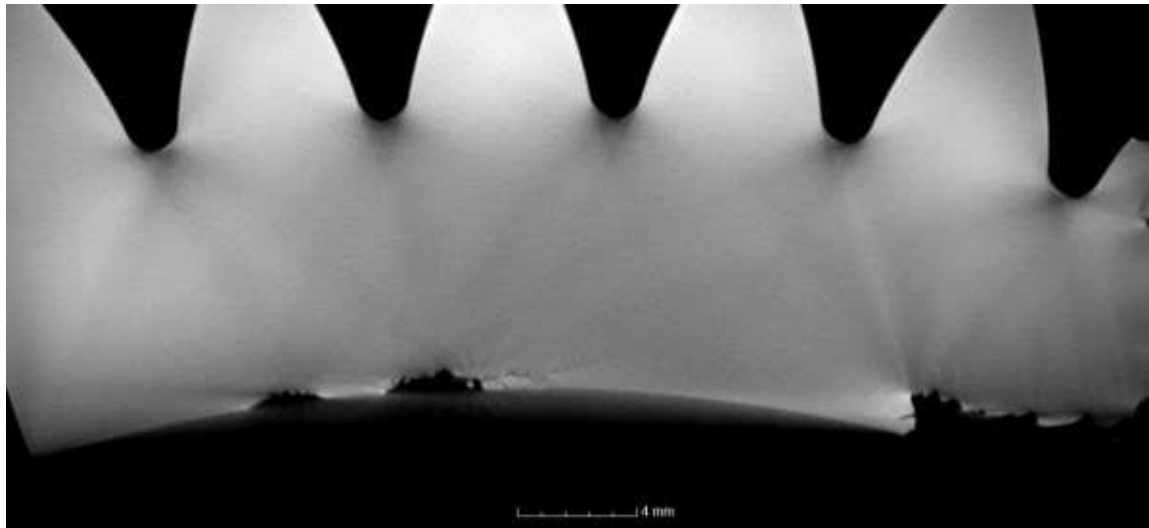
Longitudinal slice from CT-scan showing several cracks below the surface of the outer race. One crack runs below the surface between spalls (areas of surface damage). Photo: CT-scan from AIBN/Southampton University
